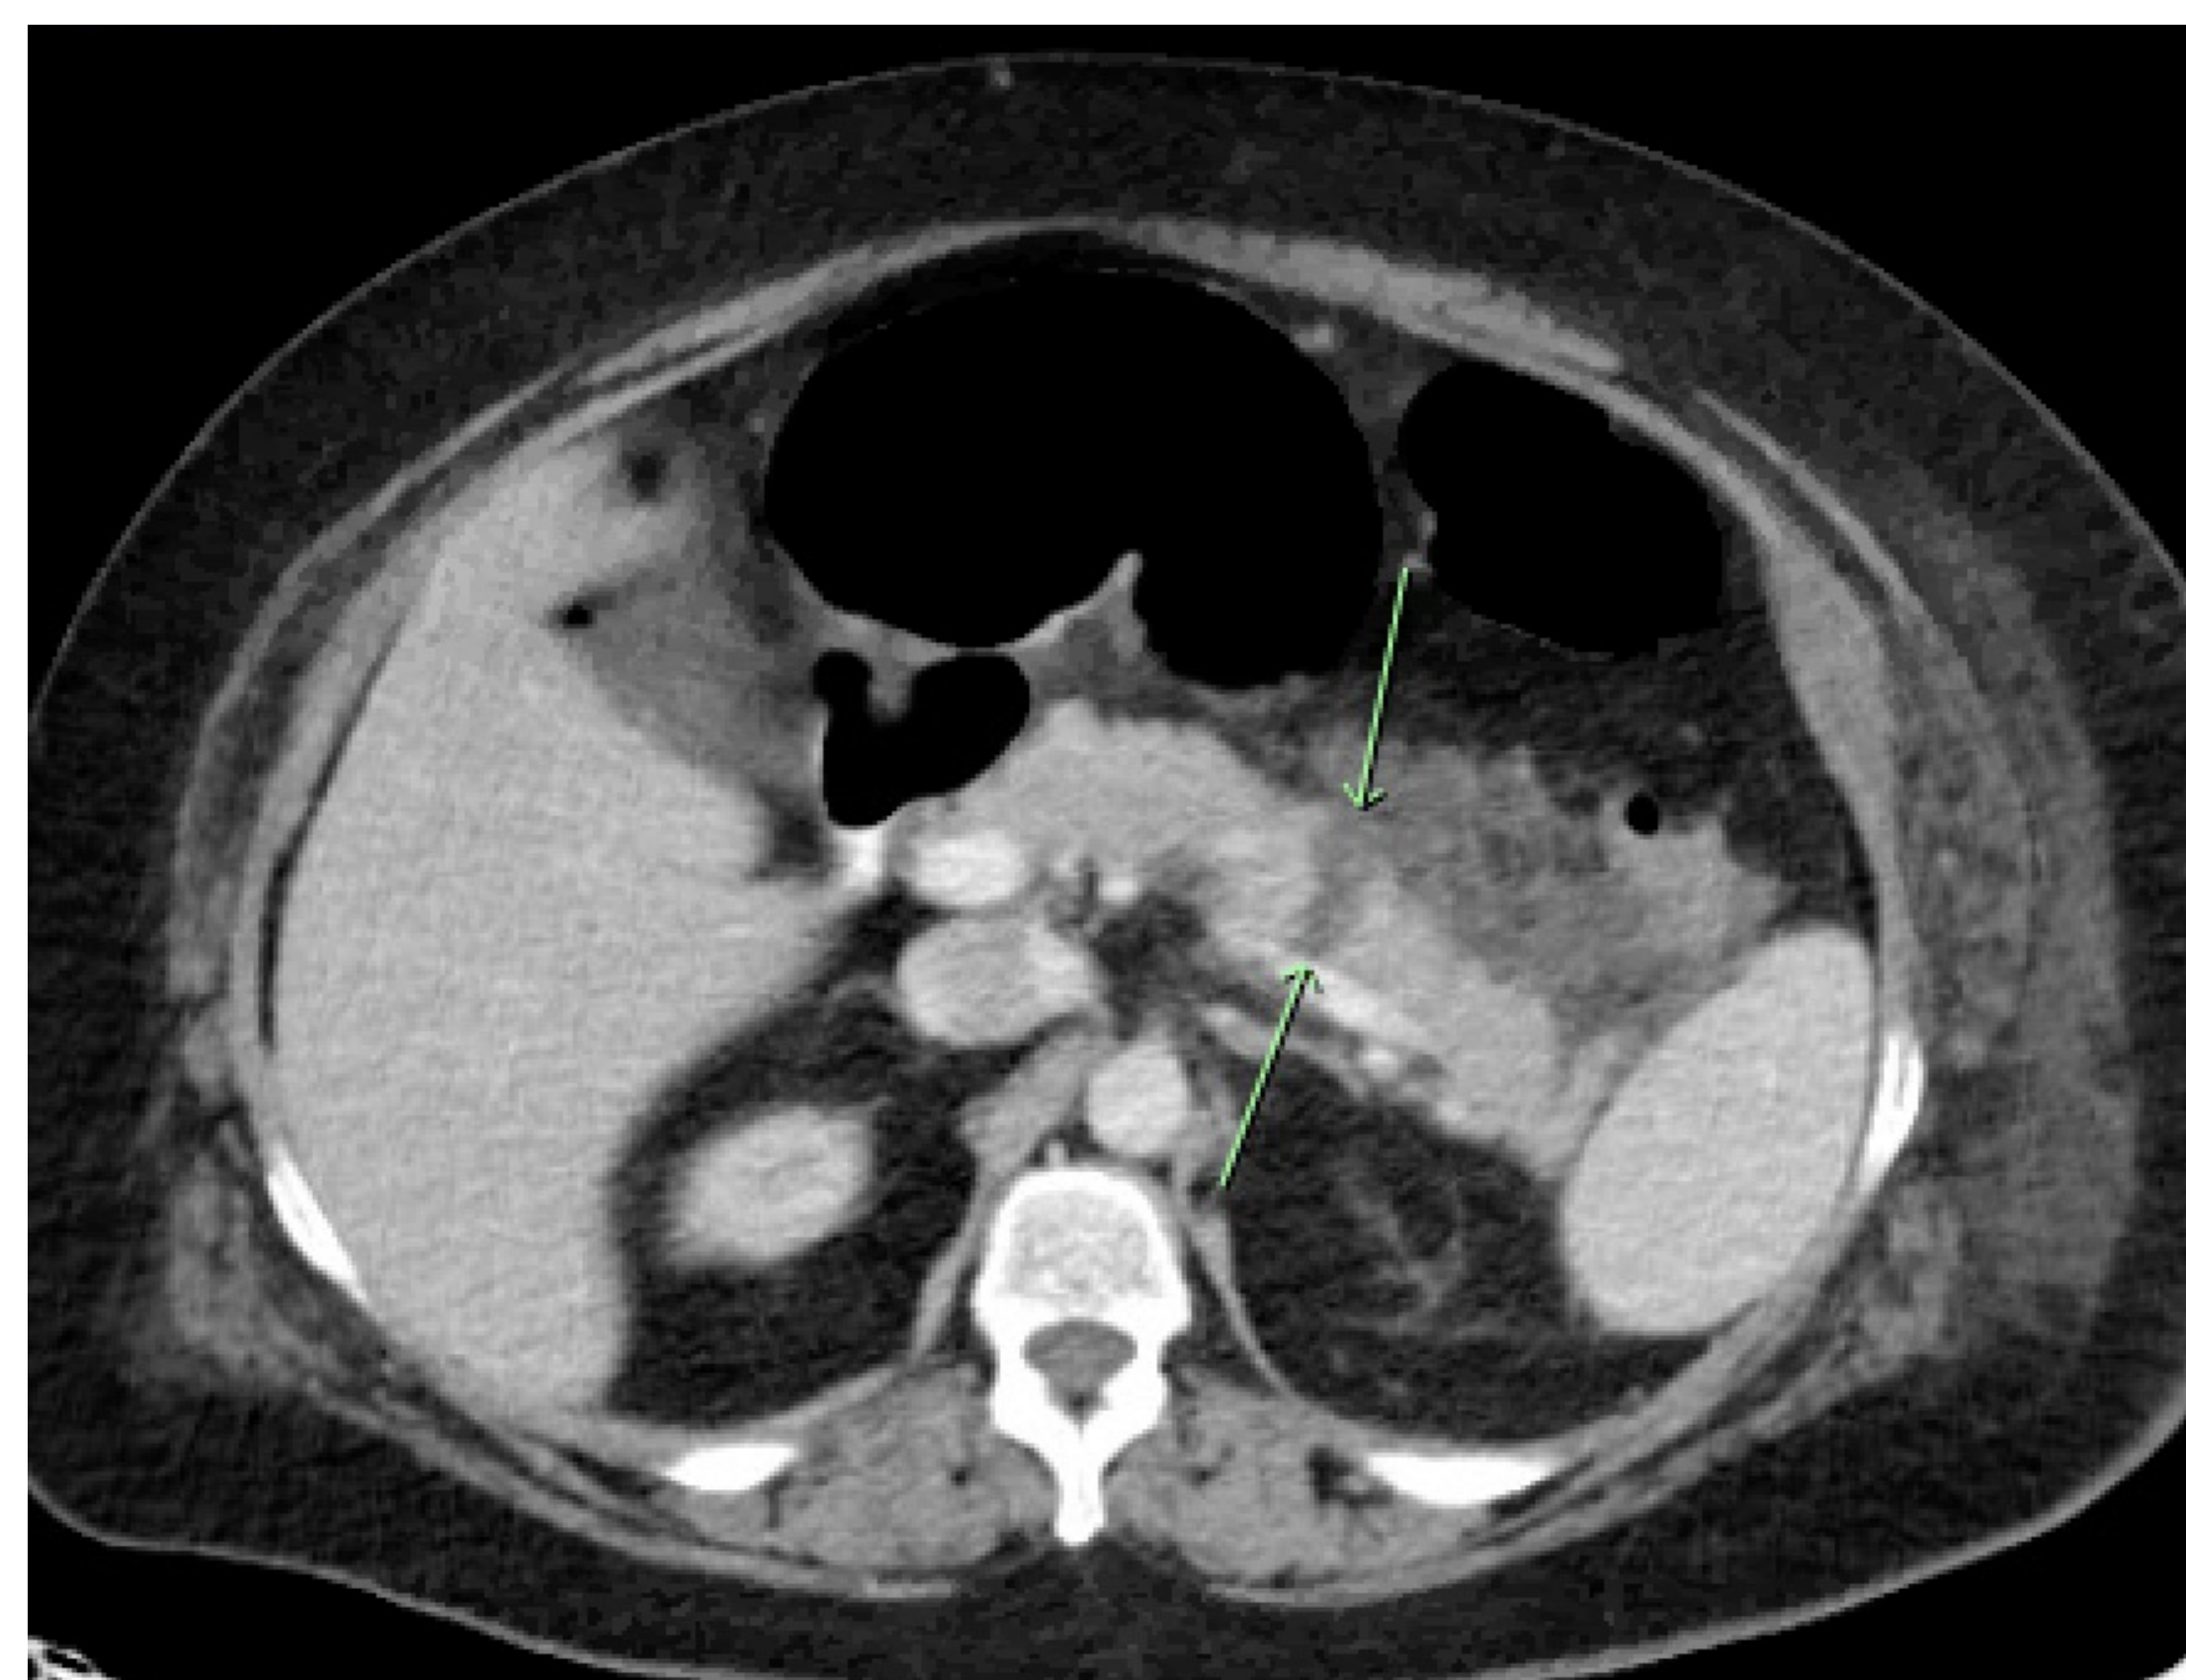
CT C/A/P demonstrating peripancreatic stranding and fluid with a hypodense band within the pancreas concerning for focal injury and pancreatic leak.
